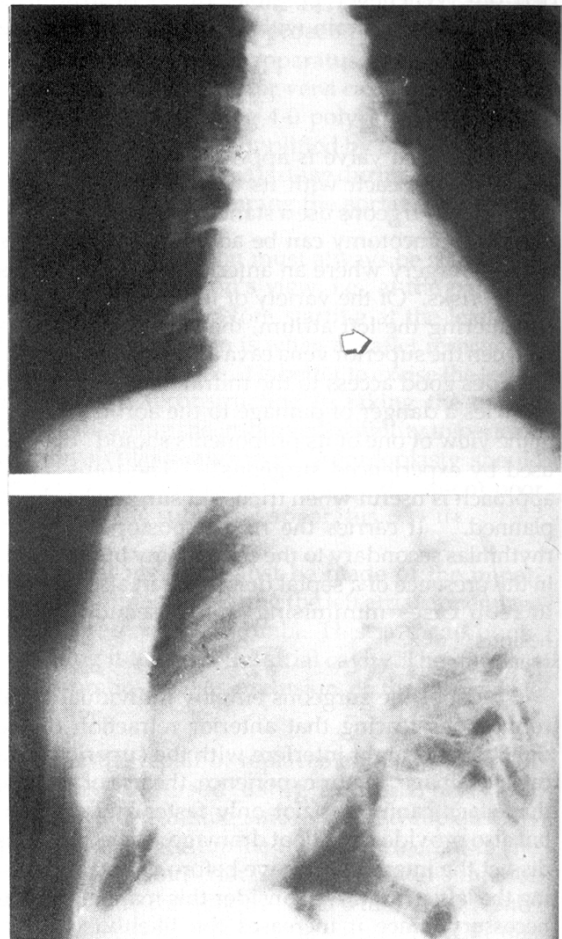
Posteroanterior and lateral chest radiographs showing the round homogenous shadow in the left lower lobe.
